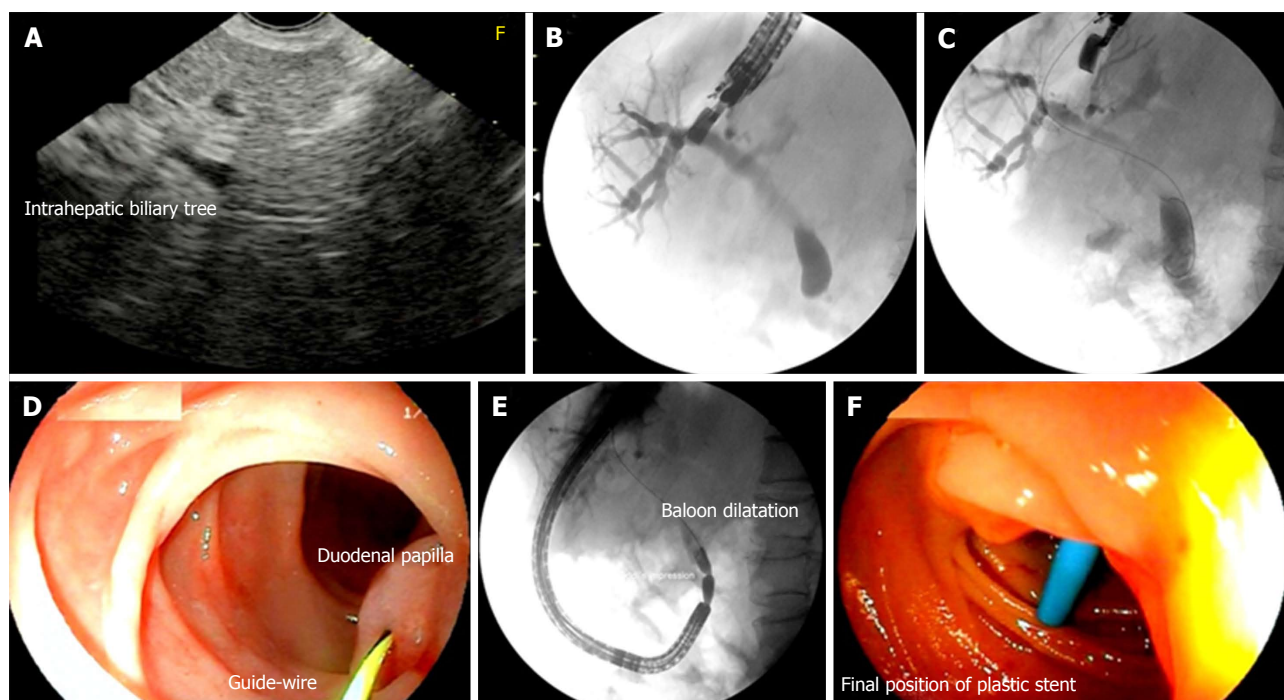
Patient with acute pancreatitis after cholecystectomy and Billroth II gastrectomy. Endosonography (EUS)-guided rendez-vous technique. A: EUS image with dilation of the intrahepatic biliary duct; B: EUS-guided cholangiography; C: Insertion of the guidewire across the duodenal papilla and positioning in the duodenum; D: Capture of the guidewire with a frontal view endoscope; E: Balloon dilatation of the duodenal papilla; F: Insertion of a 10 Fr plastic stent.
